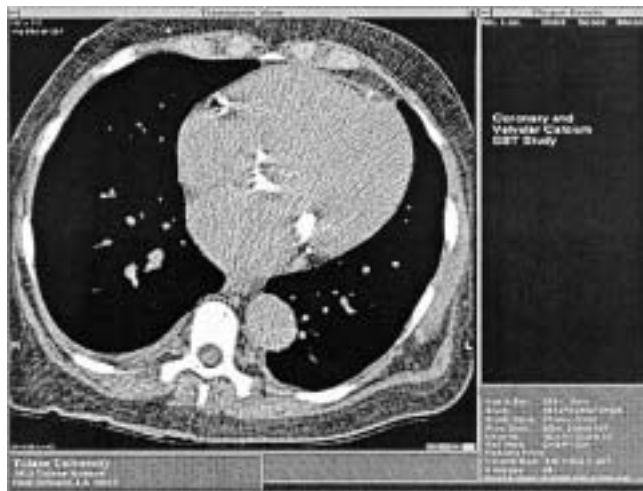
Thoracic transverse computed tomography section of a 56-year-old man undergoing maintenance hemodialysis. Note the heavy calcification of aortic valve (AoV), mitral valve (MV) and portion of the right coronary artery (RCA). The computer software highlights in yellow all tissues with a radiological density above 130 Hounsfield units for easier visualization.
